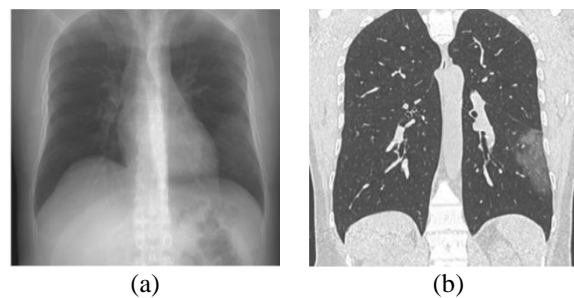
High-definition images of a 41-year-old male patient with unilateral COVID-19 pneumonia (a) X-ray and (b) computed tomography [21]
